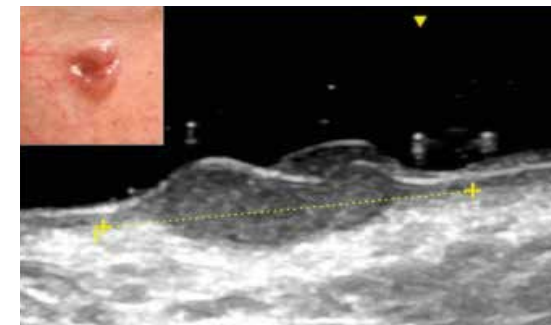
High frequency ultrasound image of a nodular basal cell carcinoma.
